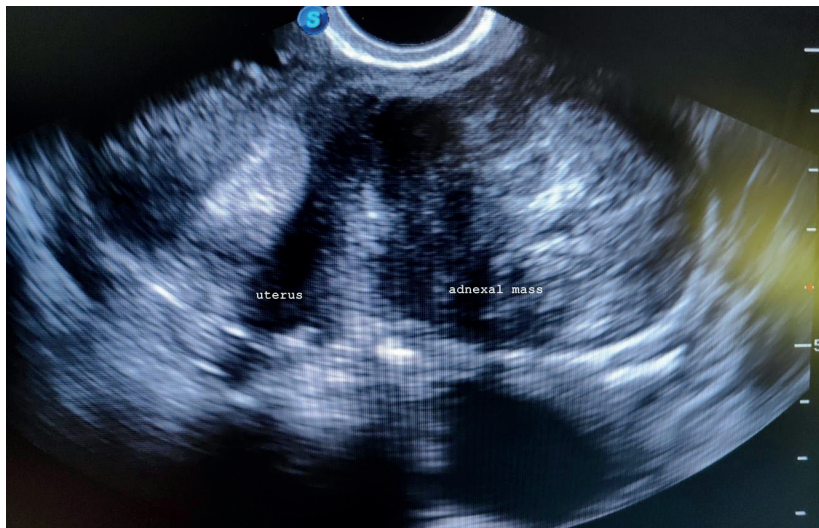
The figure shows the transvaginal ultrasound image; a 9 cm, well-circumscribed heterogeneous right adnexal mass, appearing separate from the uterus.
